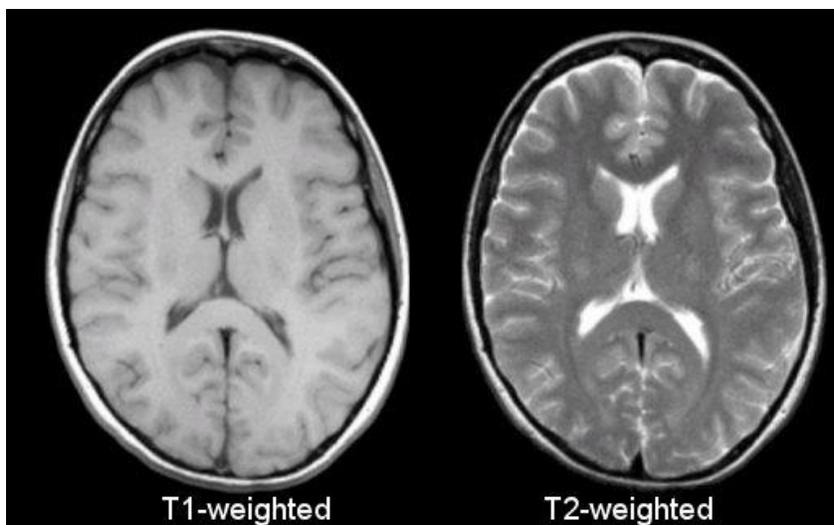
Two types of MRI imaging.
